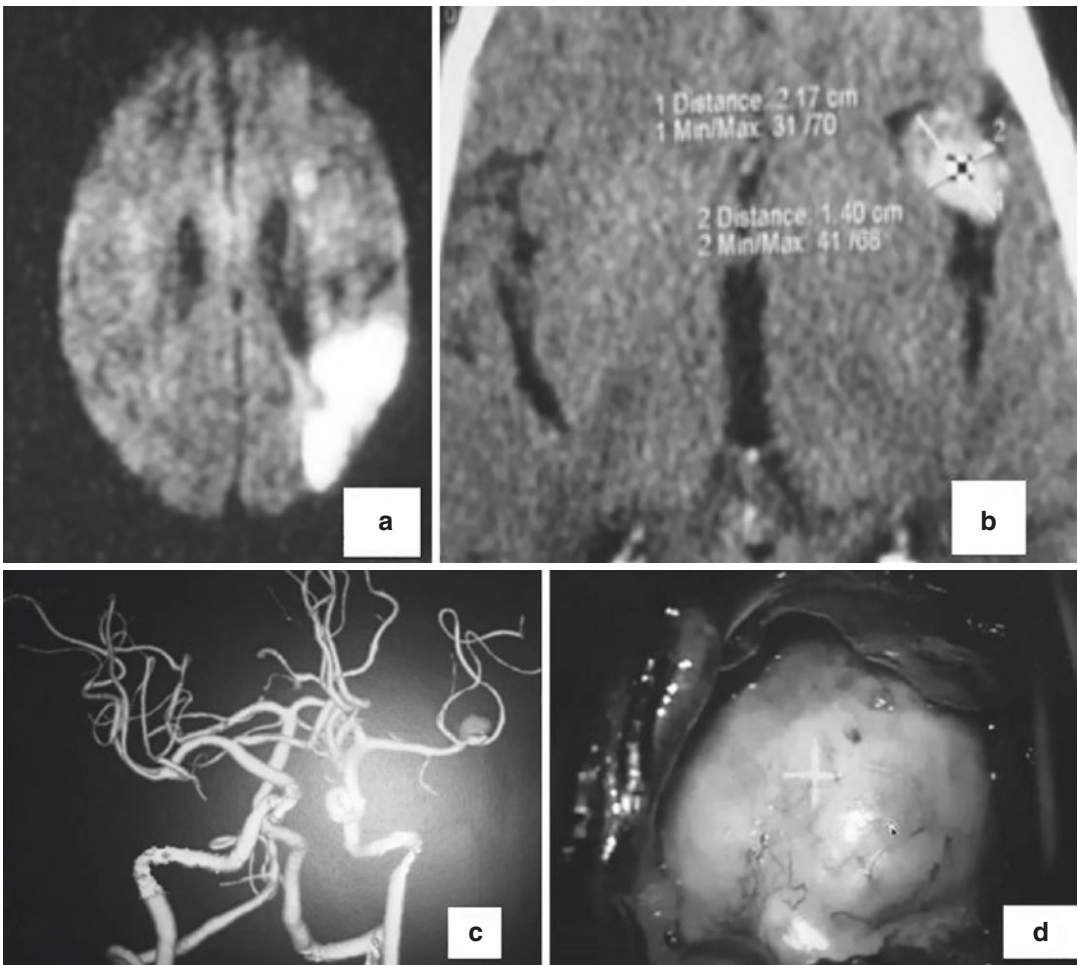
(a) Shows MR Diffusion showing infarct. (b) shows CT brain showing the thrombosed aneurysm. (c) Shows CTA with a left distal MCA thrombosed aneurysm. (d) Shows the intraoperative picture of a thrombosed distal MCA aneurysm
